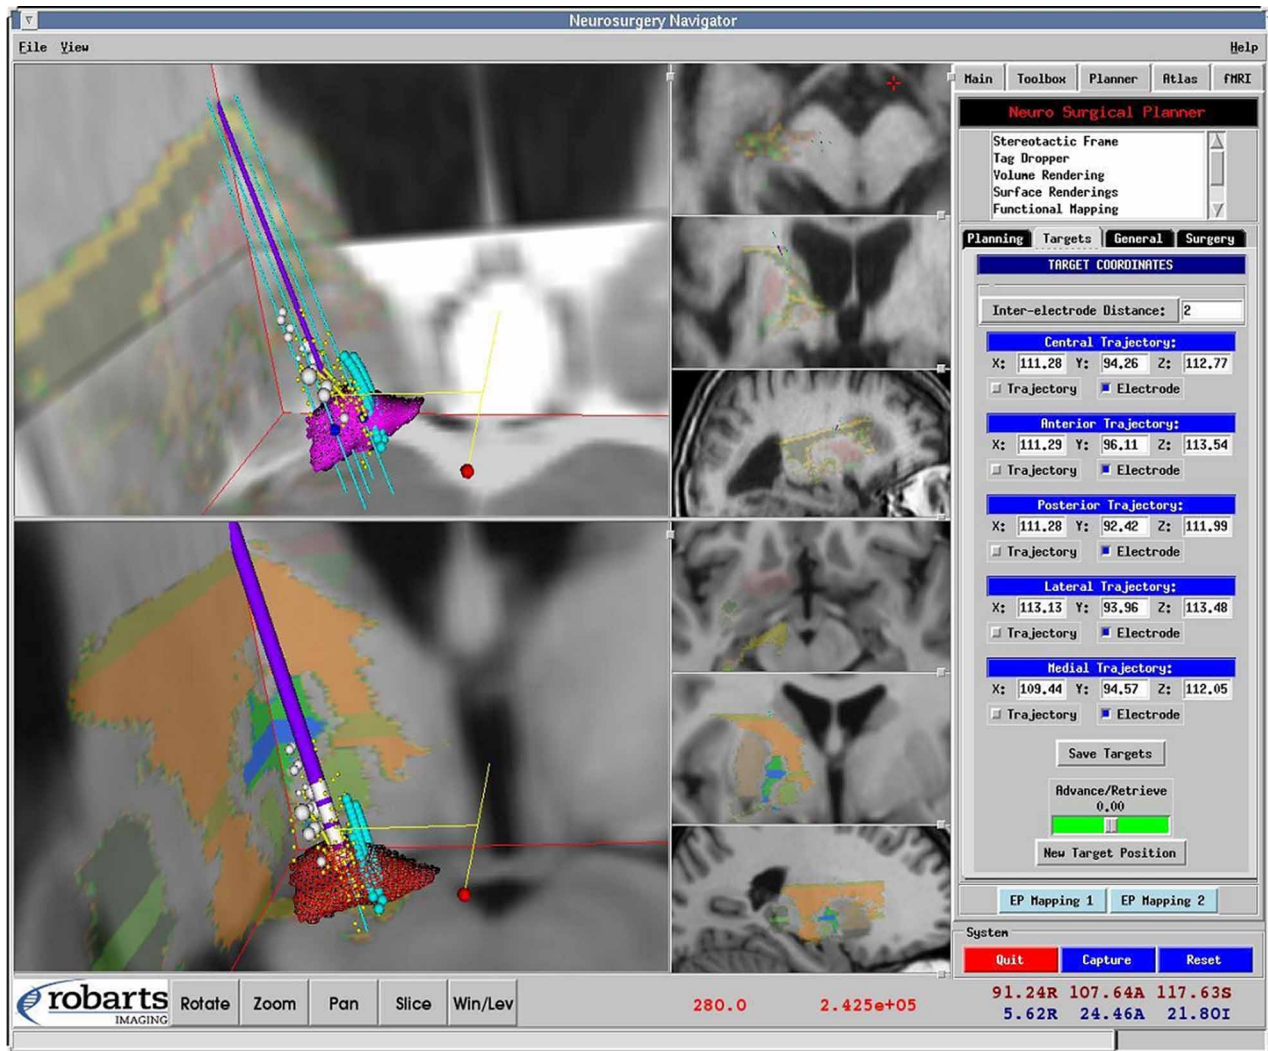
The primary graphical user interface of the system displays the 3D image volume and 2D slices of a patient (top) and those of the standard brain template (bottom). The digitized atlas is registered and fused with each image. A T2-weighted image fused with the patient image is also shown. The control panel shows the tip locations for the five probes. [Color version available online.]
